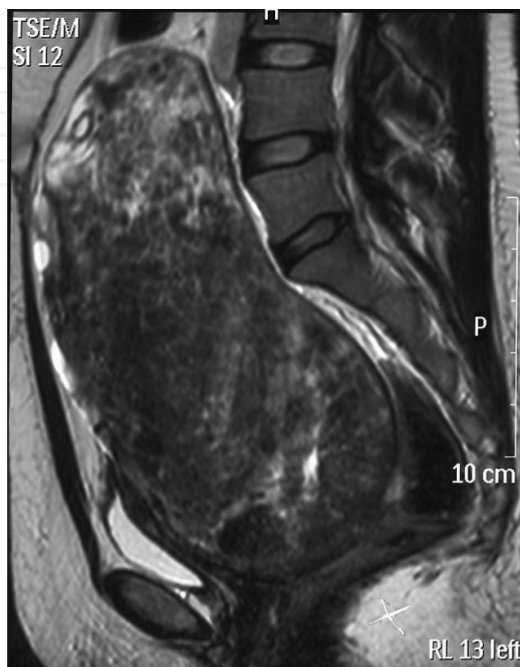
Sagittal T2 weighted MR image showing a large fibroid mass extending to upper endplate of lumbar spine. Madhuri TK, Kamran W, Walker W, Butler-Manuel S. Synchronous *uterine* artery embolization and laparoscopic myomectomy for massive *uterine* leiomyomas. JSLS.2010 Jan-Mar;14(1):120- 2.
